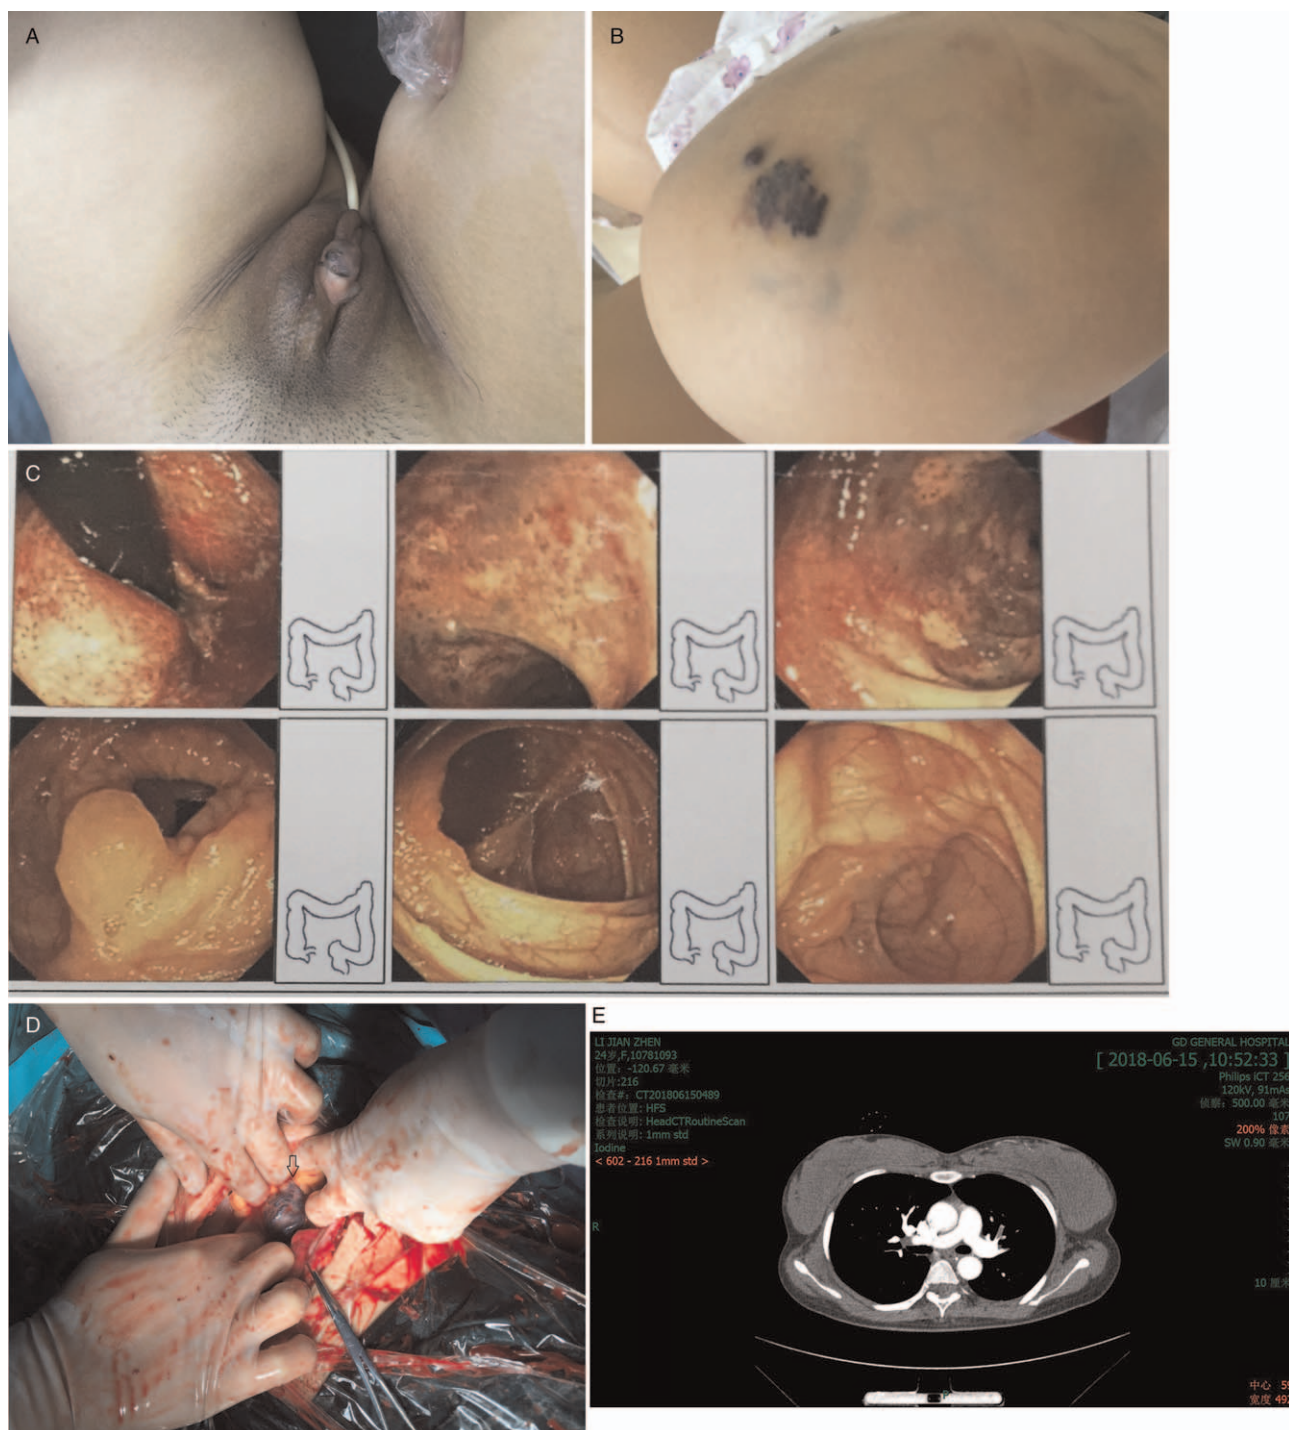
Representative images of the patient. (A) The cutaneous hemangiomas called “blue rubber bleb” involving in the vulva. (B) “Blue rubber bleb” in the skin of knee. (C) The manifestation of “blue rubber bleb” under the colonoscopy. (D) A hemangioma lesion was present on the surface of the intestine (the arrow). (E) An extensive pulmonary embolism by CT scan. CT: Computed tomography.
